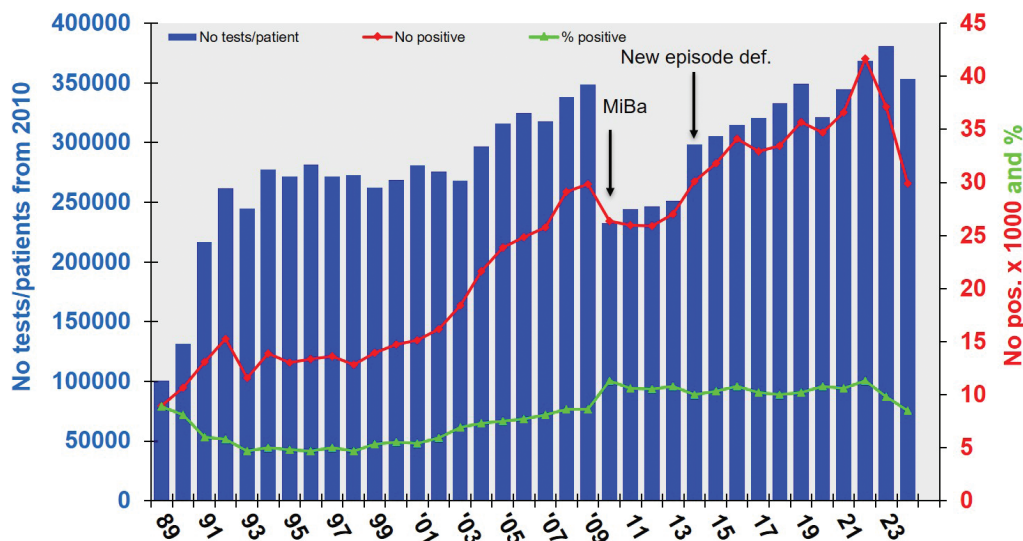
Number of *Chlamydia trachomatis* tests/diagnosed patients, laboratory-confirmed tests, and positive rates, Denmark, 1989–2024. Bars represent number of CT tests (1989–2009) and number of patients tested for CT (2010–2024), red line indicates number of positive tests (1989–2009) and number of positive episodes (2010–2024), green line indicates positive rate.
